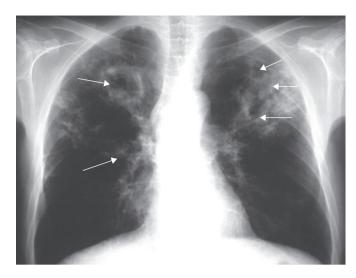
Chest radiograph showing extensive cavitary tuberculosis (arrows).
